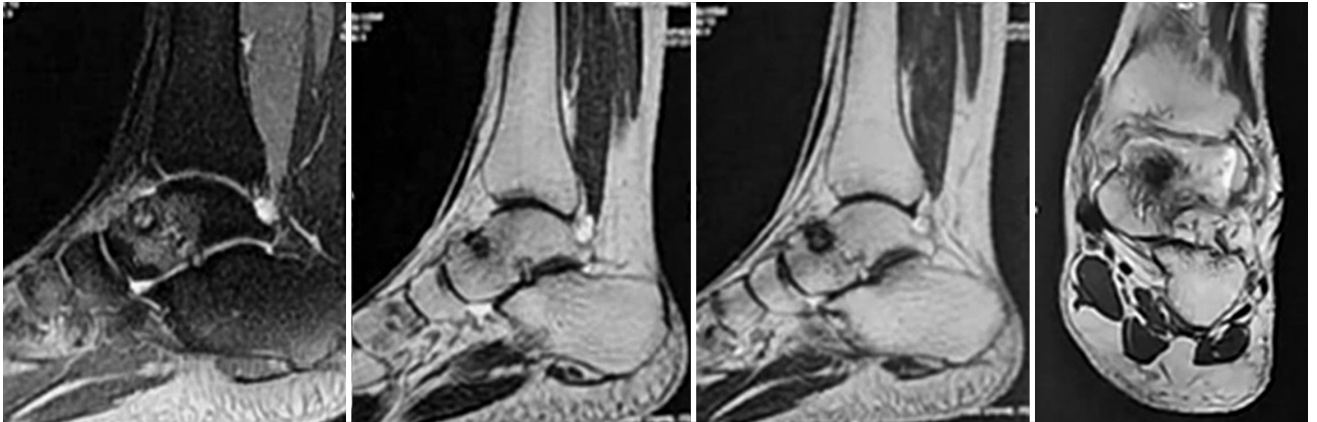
Magnetic resonance imaging showing osteoid osteoma lesion over the talar neck with surrounding edema.
